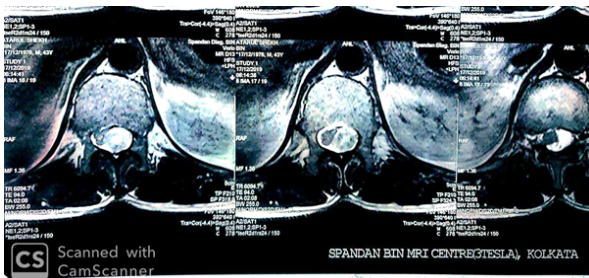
Axial section of MRI dorsal spine showing IDEM at D12 Level
